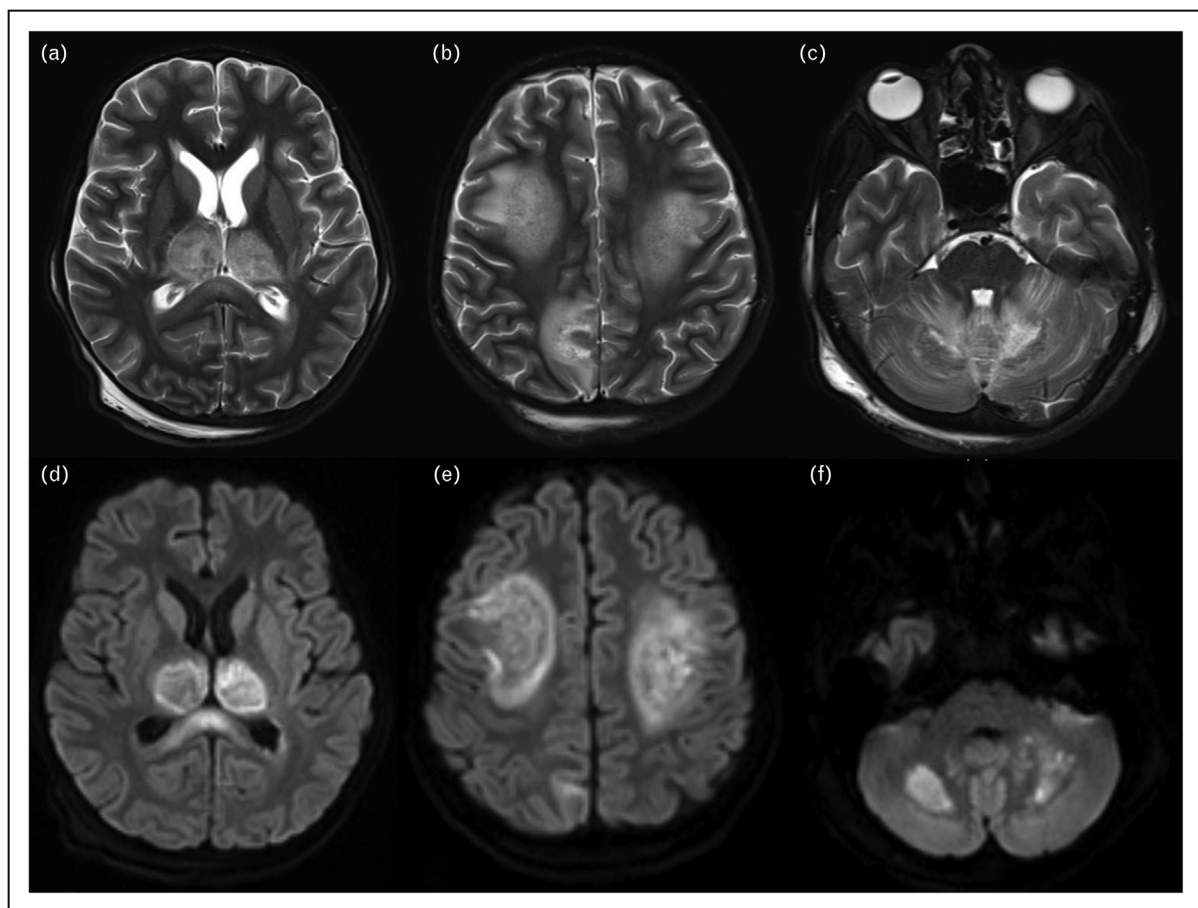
Acute necrotizing encephalitis in dengue. (a–c) MRI showing T2 Fluid Attenuated Inversion Recovery (FLAIR) sequence showing hyperintensities involving: (a) bilateral thalamus, (b) bilateral subcortical white matter involving the frontal and parietal lobes, (c) cerebellum; (d–e) corresponding areas in diffusion-weighted imaging showing hyperintensities suggestive of vasogenic oedema.
